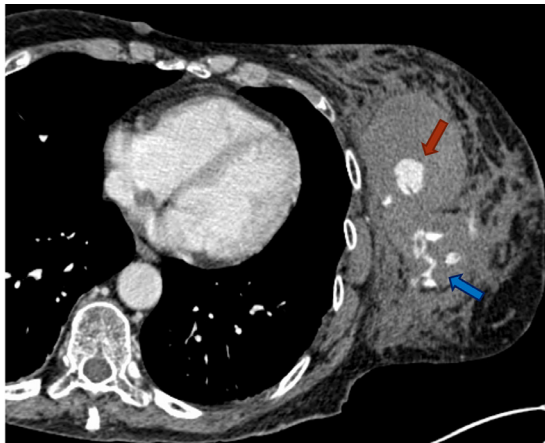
Axial CTA showed a 7 mm pseudoaneurysm (red arrow) with active arterial extravasation (blue arrow) surrounded by the left breast hematoma. “(Color version of figure is available online)”
